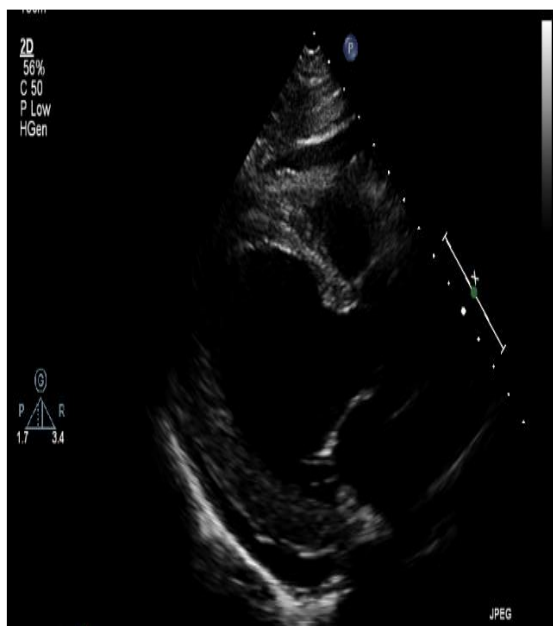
Transthoracic echocardiography (parasternal long-axis view) obtained at presentation demonstrating marked left ventricular dilatation with diffuse global hypokinesis and severe left ventricular systolic dysfunction. The estimated left ventricular ejection fraction was approximately 10%.
